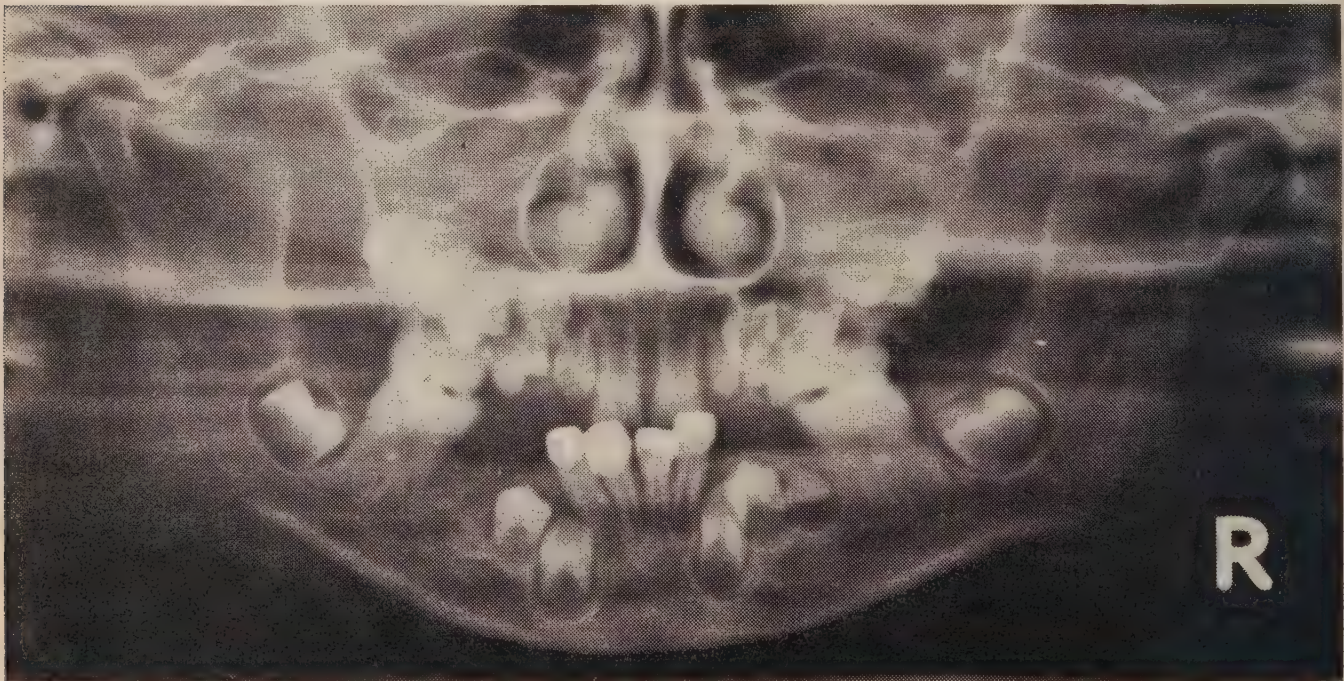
Panoramic radiograph produced by the Rotagraph. (Updegrave, W.J. D. Radiog. & Photog. 36:75, 1963.)
